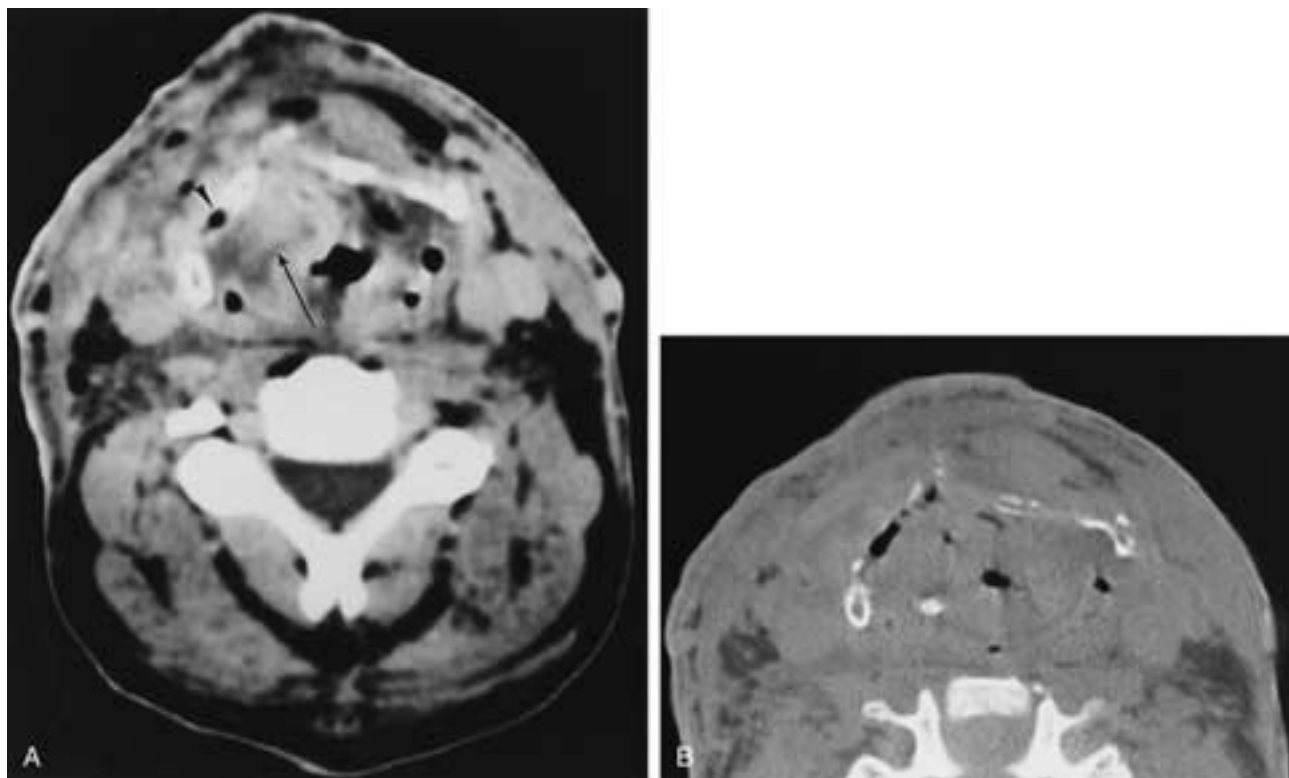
Axial CT, perichondritis and chondronecrosis of the thyroid cartilage after radiation therapy. A, Significant soft-tissue swelling of the wall of the larynx (*arrow*). There are gas bubbles within the thyroid cartilage (*arrowhead*). B, Bone algorithm shows partial collapse of the thyroid cartilage because of demineralization and chondronecrosis.
